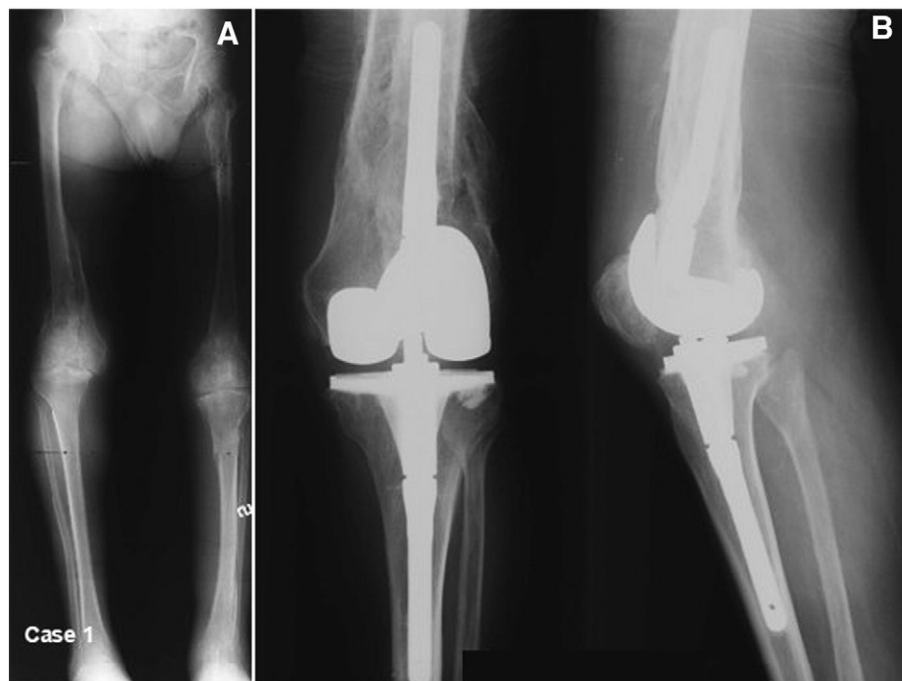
Case 1. (A) Bilateral knee osteoarthritis in sequelae of knee osteotomy. In (B) is shown correct positioning of the prosthetic components without radiographic signs of loosening.
